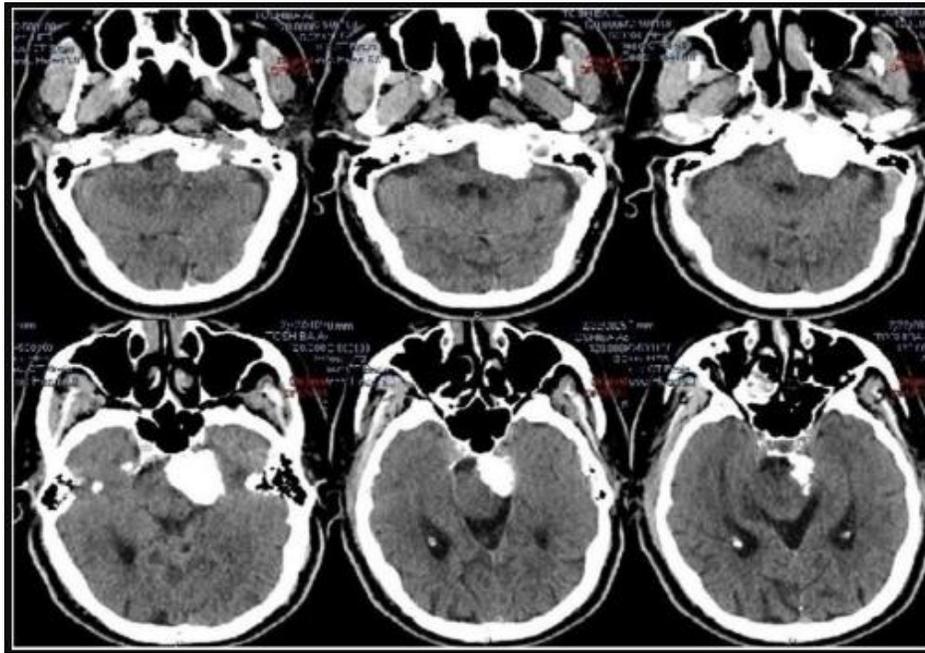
Computed tomography brain scan (CT brain scan) reveals Left CPA extra-axial well-defined dense calcified meningioma indenting the pons left aspect. There are mild global cerebral involutational changes in the term of prominent extra-axial CSF spaces.
